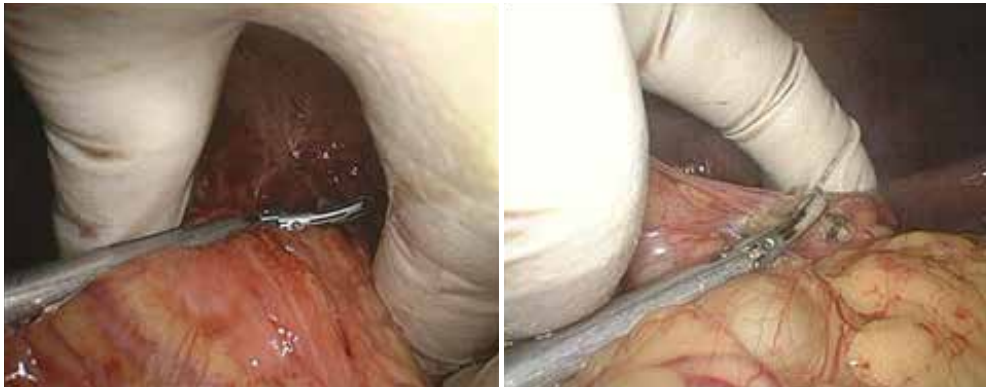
Dividing inflammatory adhesions using ultrasonic scalpel with hand-assist.
